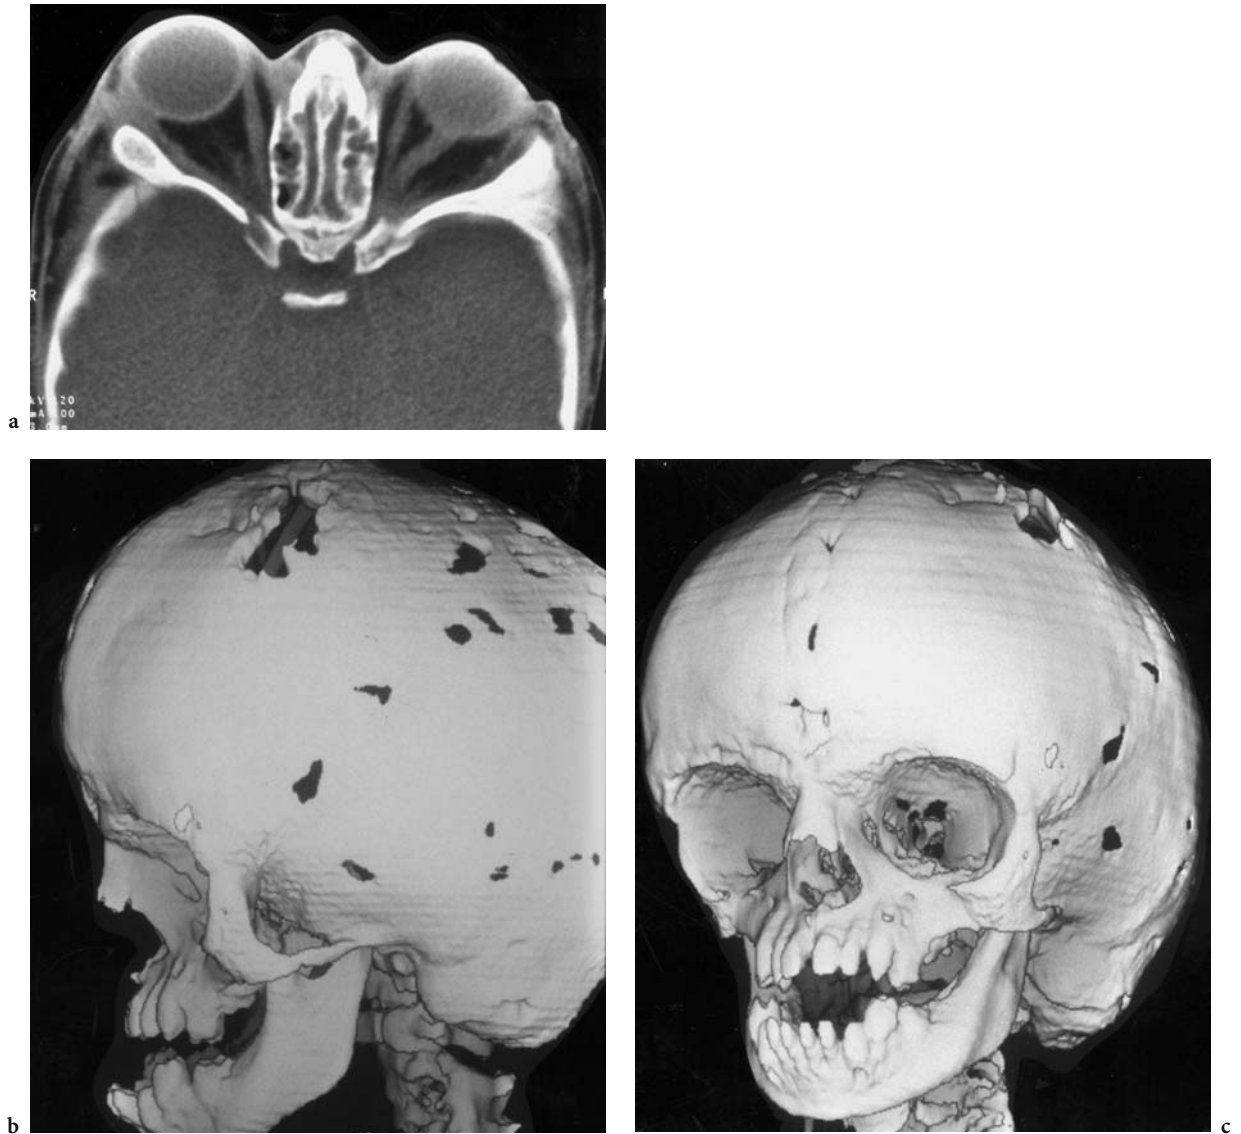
A 1.5-year-old girl with craniofacial dysostosis presenting with recurrent prolapse of both globes from the orbit (up to 30 times per day!). Diagnosis: Crouzon syndrome. CT: a Axial view, demonstrating bilateral proptosis caused by flattened orbits. b Lateral view of 3D-reconstruction, showing the absence of an orbital floor and extremely small maxillary bone/sinus. c Frontal view (3D) from the left
